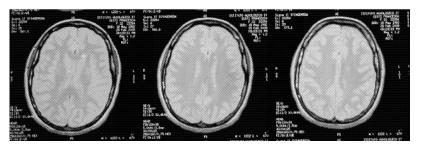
Radiological and MRI Exams, respectively, before and after treatment.
